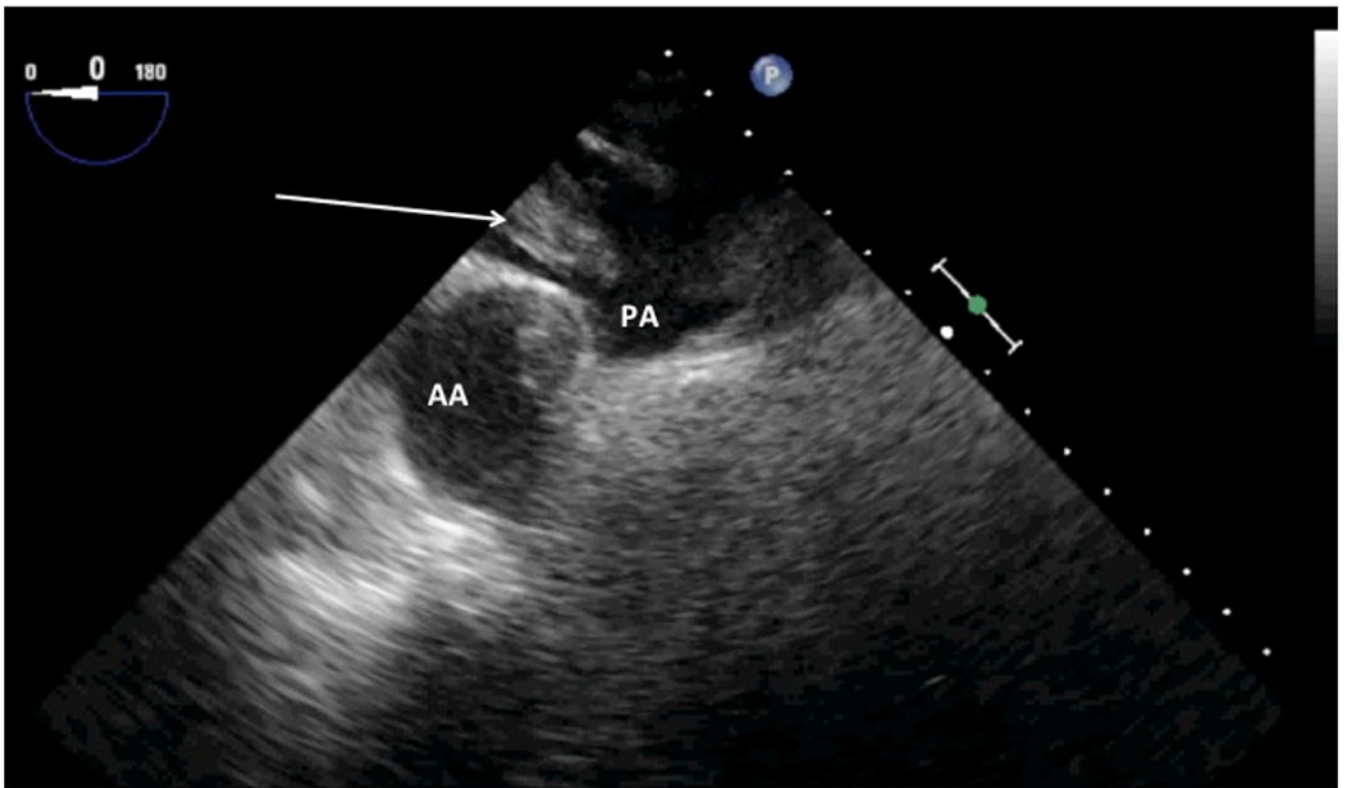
Mid-esophageal ascending aorta transesophageal echocardiographic view shows pulmonary embolism in the right pulmonary artery (arrow). AA = ascending aorta; PA = pulmonary artery
